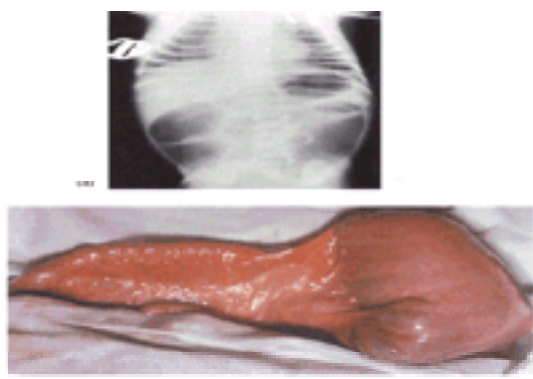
(a) Plain abdominal radiograph in ileal atresia. (b) Ileal atresia type II.
